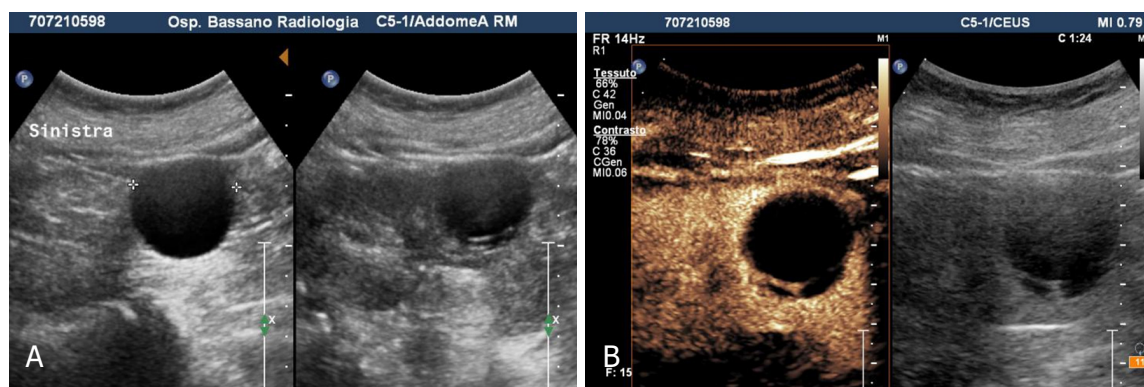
Bosniak 2F cyst. A: Grey scale sonography shows in the mid portion of the left kidney cystic lesion with thin hyperechoic septum; B: Contrast enhanced sonography reveal homogeneous enhancement of the septum without parietal nodule
